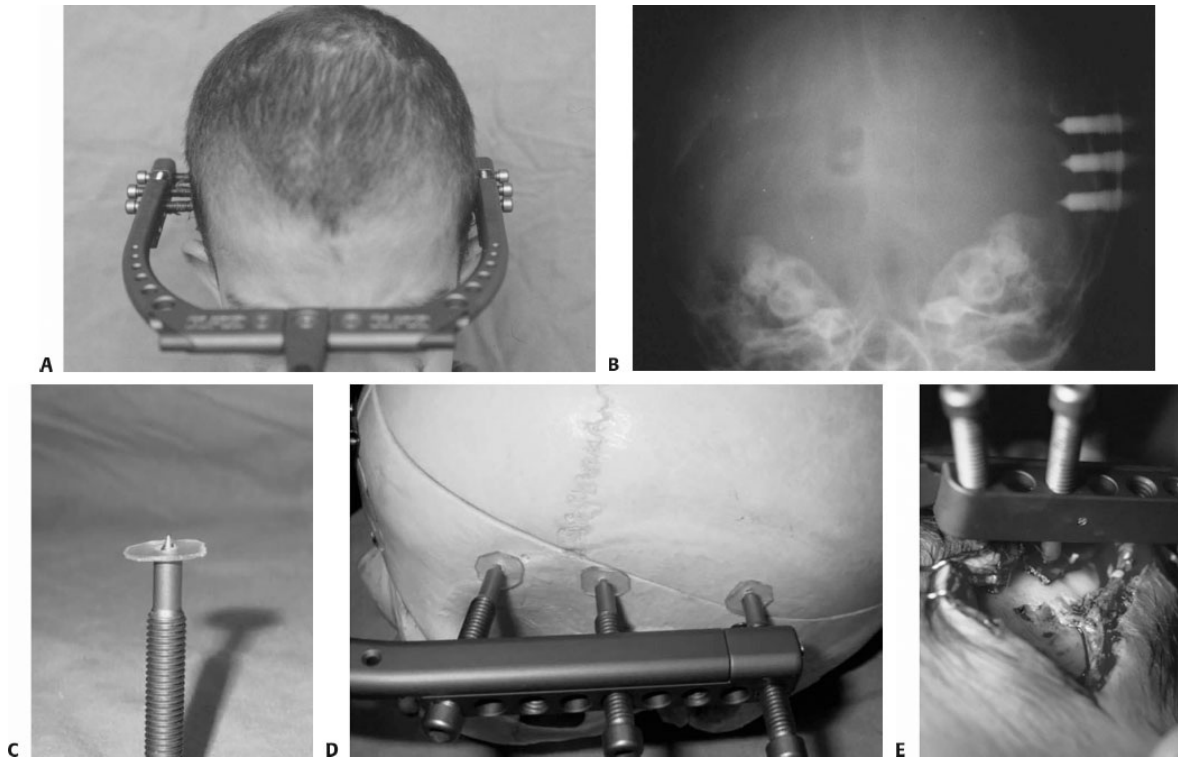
• Photograph (A) and plain x-ray (B) of a patient with intracranial migration of fixation pins after trauma. The distraction and recovery periods were completed without complication. C–E. Resorbable plates were placed in both temporal areas for pin fixation.
